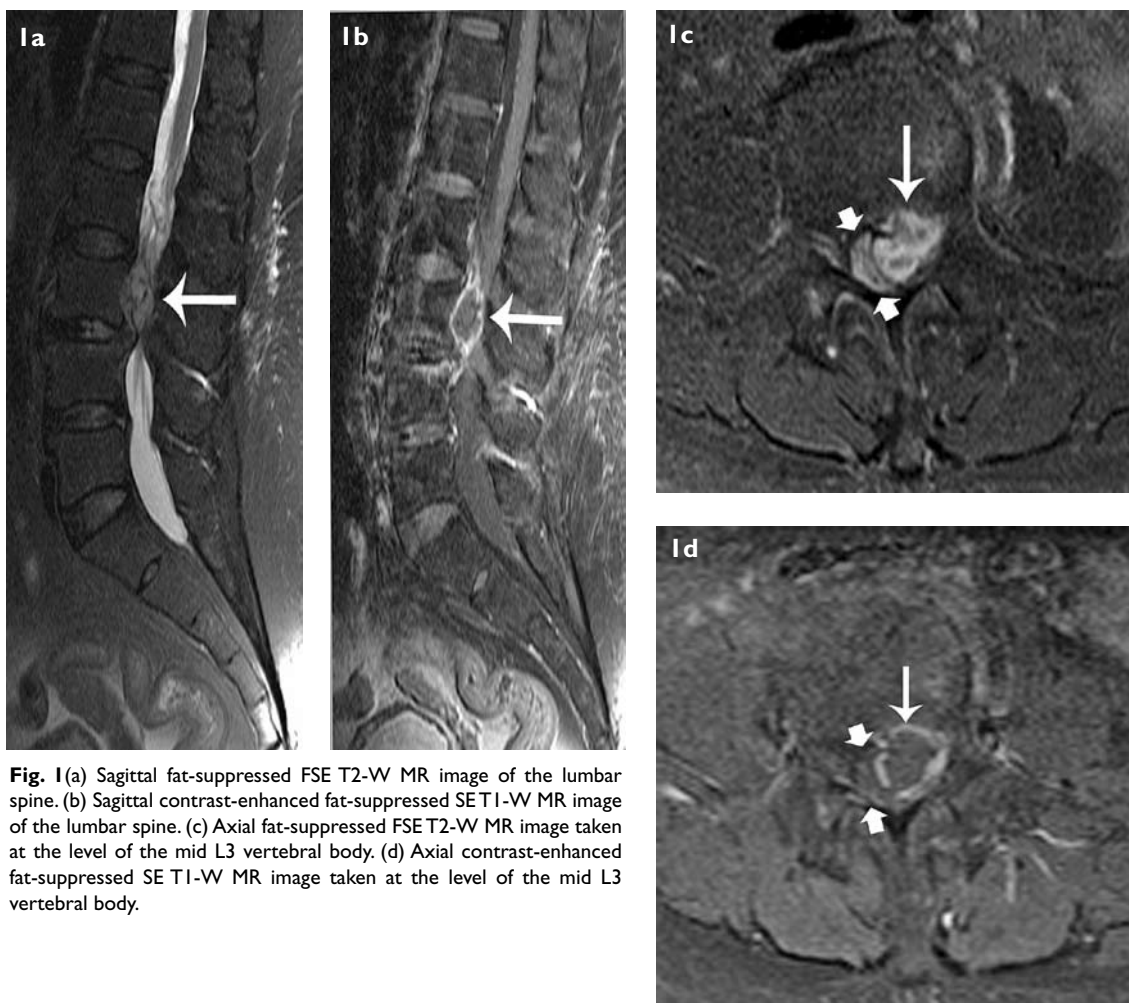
(a) Sagittal fat-suppressed FSE T2-W MR image of the lumbar spine. (b) Sagittal contrast-enhanced fat-suppressed SE T1-W MR image of the lumbar spine. (c) Axial fat-suppressed FSE T2-W MR image taken at the level of the mid L3 vertebral body. (d) Axial contrast-enhanced fat-suppressed SE T1-W MR image taken at the level of the mid L3 vertebral body.
